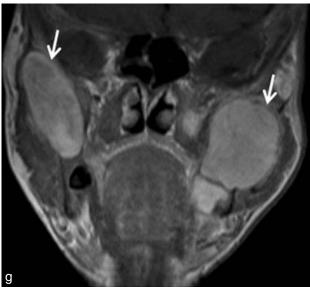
Axial (a,b,e,f) and coronal (c,d,g) IV contrast enhanced maxillofacial MRI shows bilateral maxillary and mandibular lesions which have heterogenous intermediate to high signal intensity on T2 w images (a,b,c,d; white arrows) and low signal intensity on
